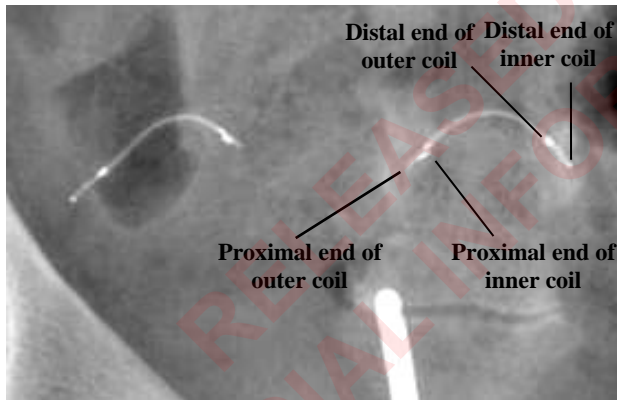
Radiograph 1: Scout Film
